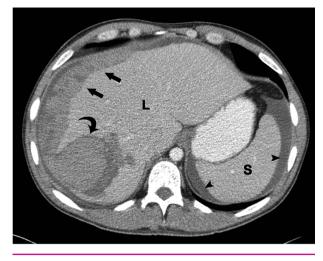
Patient #1 ten days following BMT. The patient developed severe upper right abdominal pain and hemorrhagic shock. Abdominal CT demonstrates a 7.5 cm hyperdense mass in segment 7 of the liver (curved arrow). A large subcapsular haematoma surrounds the liver (arrows), originating from this lesion. The mass and the subcapsular collection are hyperdense, representing acute blood. Free intraperitoneal fluid is noted around the spleen (arrowheads). L=liver; S=spleen
